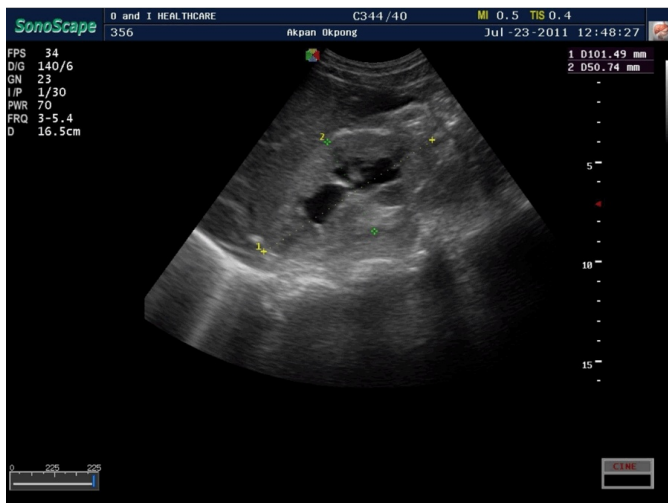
Ultrasound scan showed kidney with hydronephrosis and Grade 3 paraneural disease.
